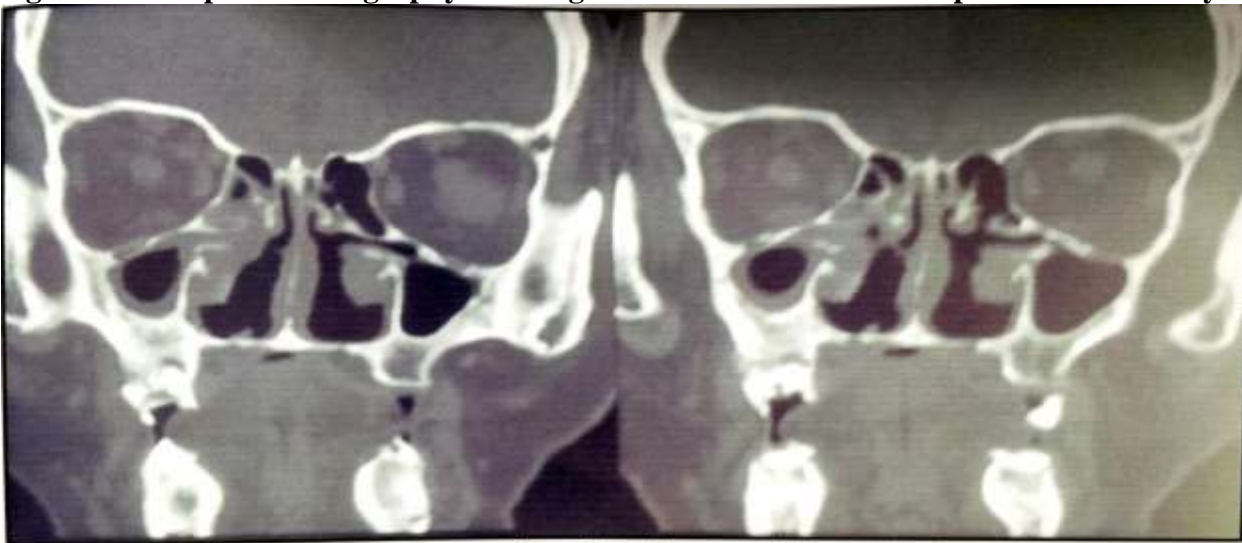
Computed tomography showing maxilla and Ethmoid involvement in a patient of mucormycosis
